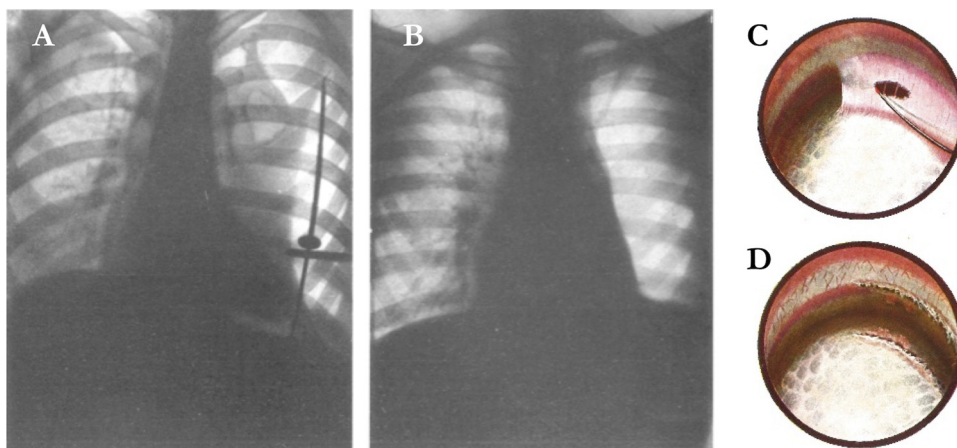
(A) Jacobaeus operation. Left anterolateral adhesion keeping a cavitary lung zone open. Radiographs taken during the intervention. The thoracoscope was introduced horizontally into the pleural cavity; cautery with the cutting edge applied to a pleuro-pulmonary adhesion at the point suitable for resection can be observed. (B) The same case after resection of the adhesion. Complete cavitary and pulmonary collapse may be observed. Another adhesion is still present that did not have an impact on the collapse and so it was not resected (from Cova, 1927 and Costantini and Redaelli, 1933, original description). (C) (D) Jacobaeus operation. The resection of a tent-shaped adhesion (from Cova, 1927 and from Cova, 1928, original description).
